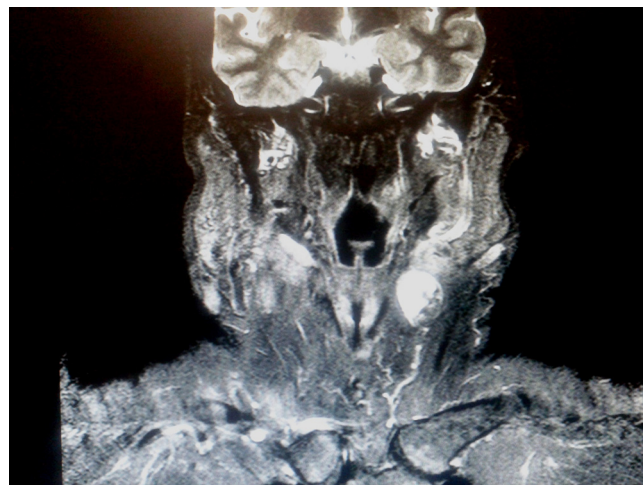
Neck MRI frontal projection.
